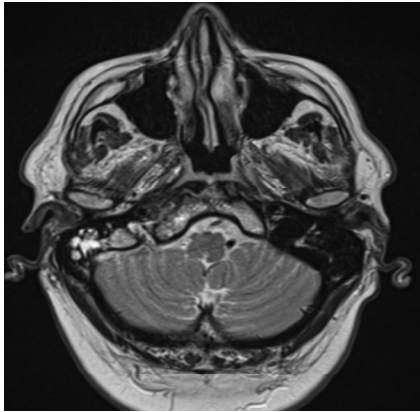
Surveillance MRI at twelve weeks after completing ten weeks of antibiotic treatment shows symmetric appearance of petroclival region, despite some marrow signal changes and abnormal enhancement in the right petroclival region extending into the right side of the nasopharynx.
